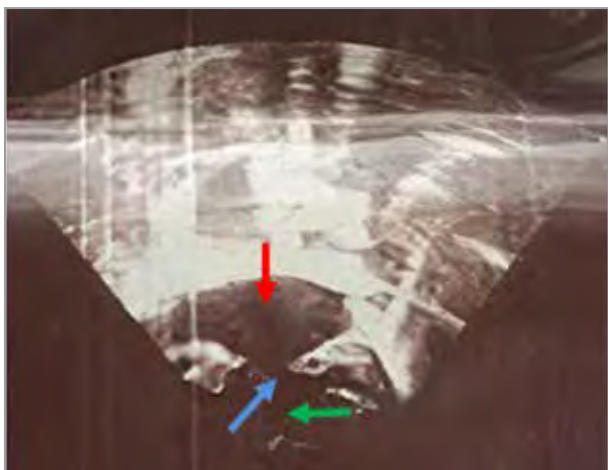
Transthoracic echocardiogram showing common atrium (red arrow), single ventricle (green arrow) and a common atrioventricular valve (blue arrow).
